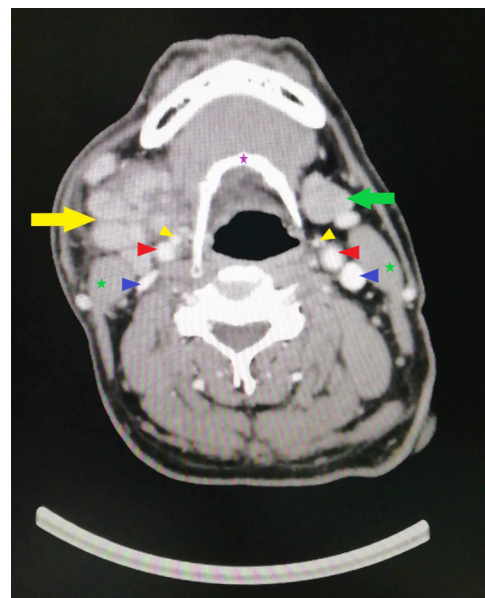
CT neck shows right submandibular gland enlargement, measuring 3.3 cm x 4.5 cm x 5.4 cm, with heterogeneous enhancement (yellow arrow). Left submandibular gland - green arrow; external carotid artery - yellow arrowhead; internal carotid artery - red arrowhead; internal jugular vein - blue arrowhead; sternocleidomastoid muscle - green star; hyoid bone - purple star.
